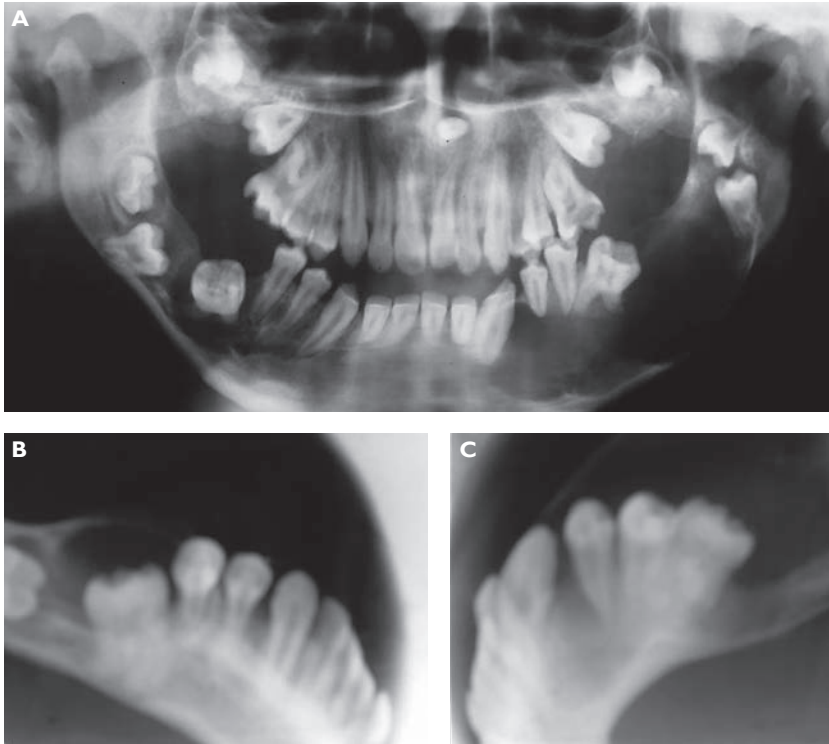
Panoramic radiographs (A) showing extensive unilocular radiolucent lesions in the mandible bilaterally, involving tooth 46 on the right, retained teeth, supernumerary teeth in the midline, and marked condylar resorption (A). Occlusal radiographs showing expansion caused by the cystic lesion in the basal cortical bone of the right mandible (B) and left mandible (C).
